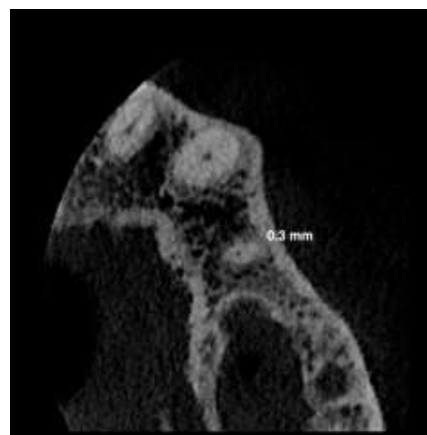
Representative image of a buccal root of first maxillary premolar showing the measurement of the diameter in a mesio-distal section. The diameter was 0.3 mm at 1 mm away from the radiographic apex.
